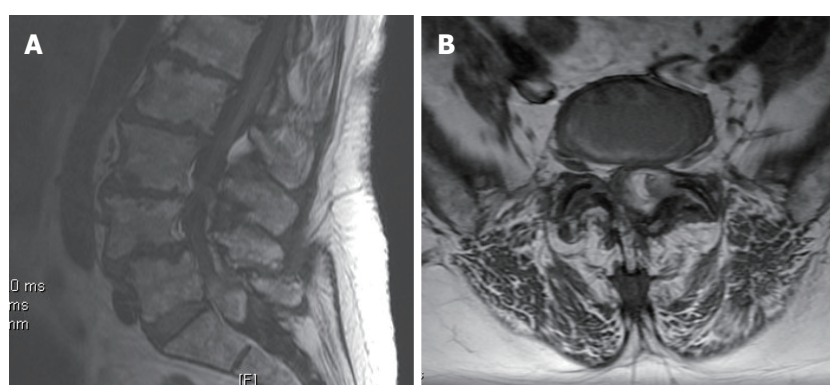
T1 weighted midsagittal (A) and axial (B) magnetic resonance imaging scan showed increased signal intensity with layering areas suggesting different stages of hematoma formation.
